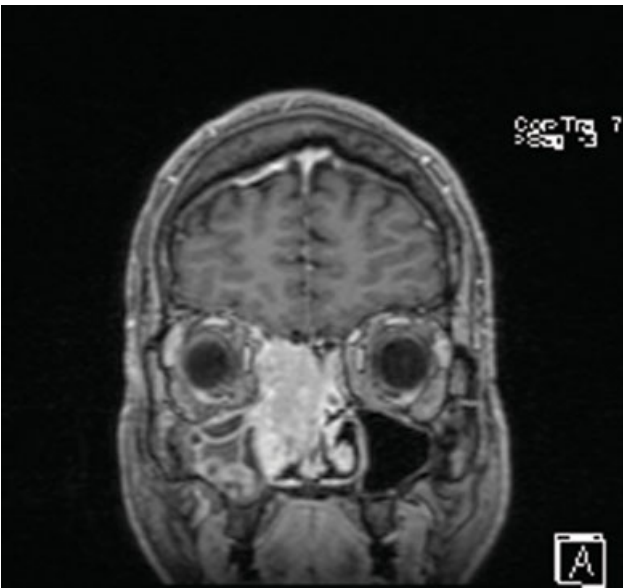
MRI T1 with contrast showing a large enhancing mass centered within the right nasal cavity abutting the orbit and the anterior base of skull.
